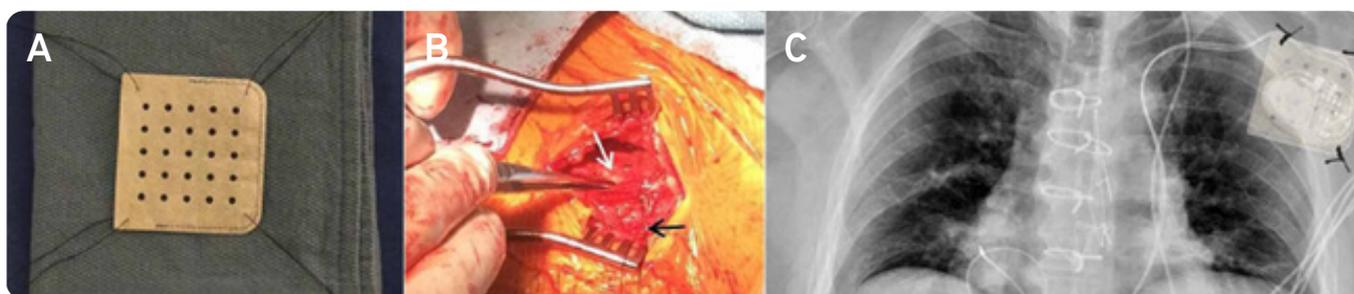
CanGaroo® pocket securement technique. (A) Silk sutures have been placed in all four corners of the envelope to demonstrate securement options. (B) The PPM has been placed in the CanGaroo® (white arrow) and a silk suture (black arrow) has been placed in one corner. (C) Anterior-posterior chest X-ray of a dual chamber PPM via a left persistent SVC with an image overlay of the CanGaroo pocket and anchoring sutures representative of a three point securement technique. | PPM, pacemaker; SVC, superior vena cava
